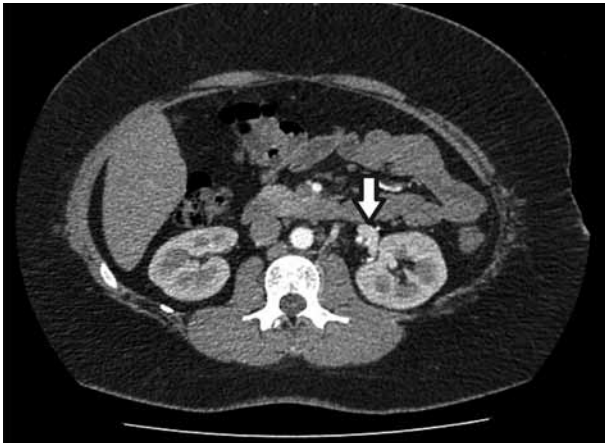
CT of abdomen showing large left-sided adrenal mass (arrow)
